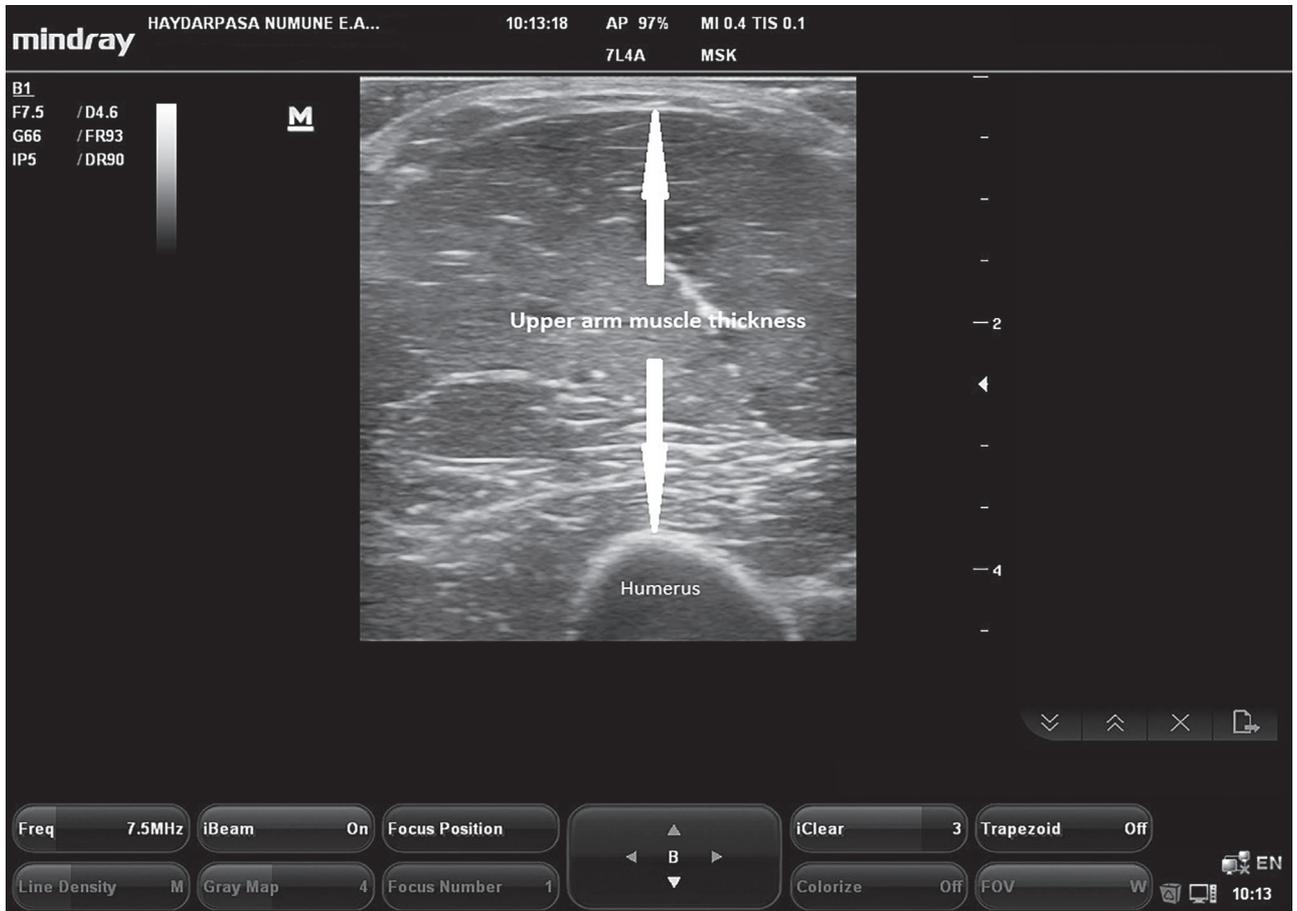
Ultrasound measurement of upper arm muscle thickness.
